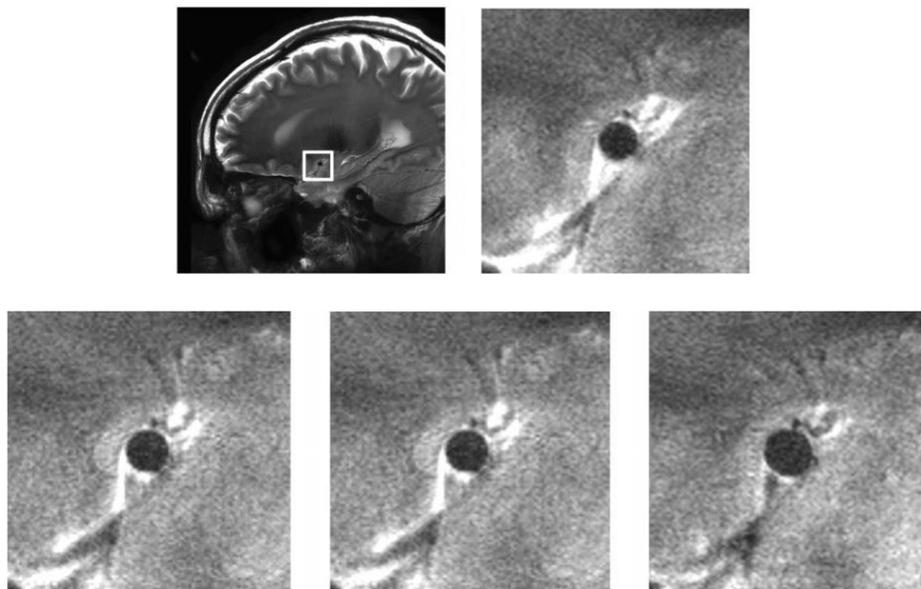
High-resolution 7-Tesla MRI scans planned perpendicular in the middle cerebral artery (MCA). Upper: the white square shows the location of the following zoomed images, zoomed image at hypocapnia (-1 kPa). Lower: zoomed imaged at baseline normocapnia (0 kPa), and hypercapnia (+1 and +2 kPa end-tidal CO<sub>2</sub> respectively) (Verbree et al., 2014).
